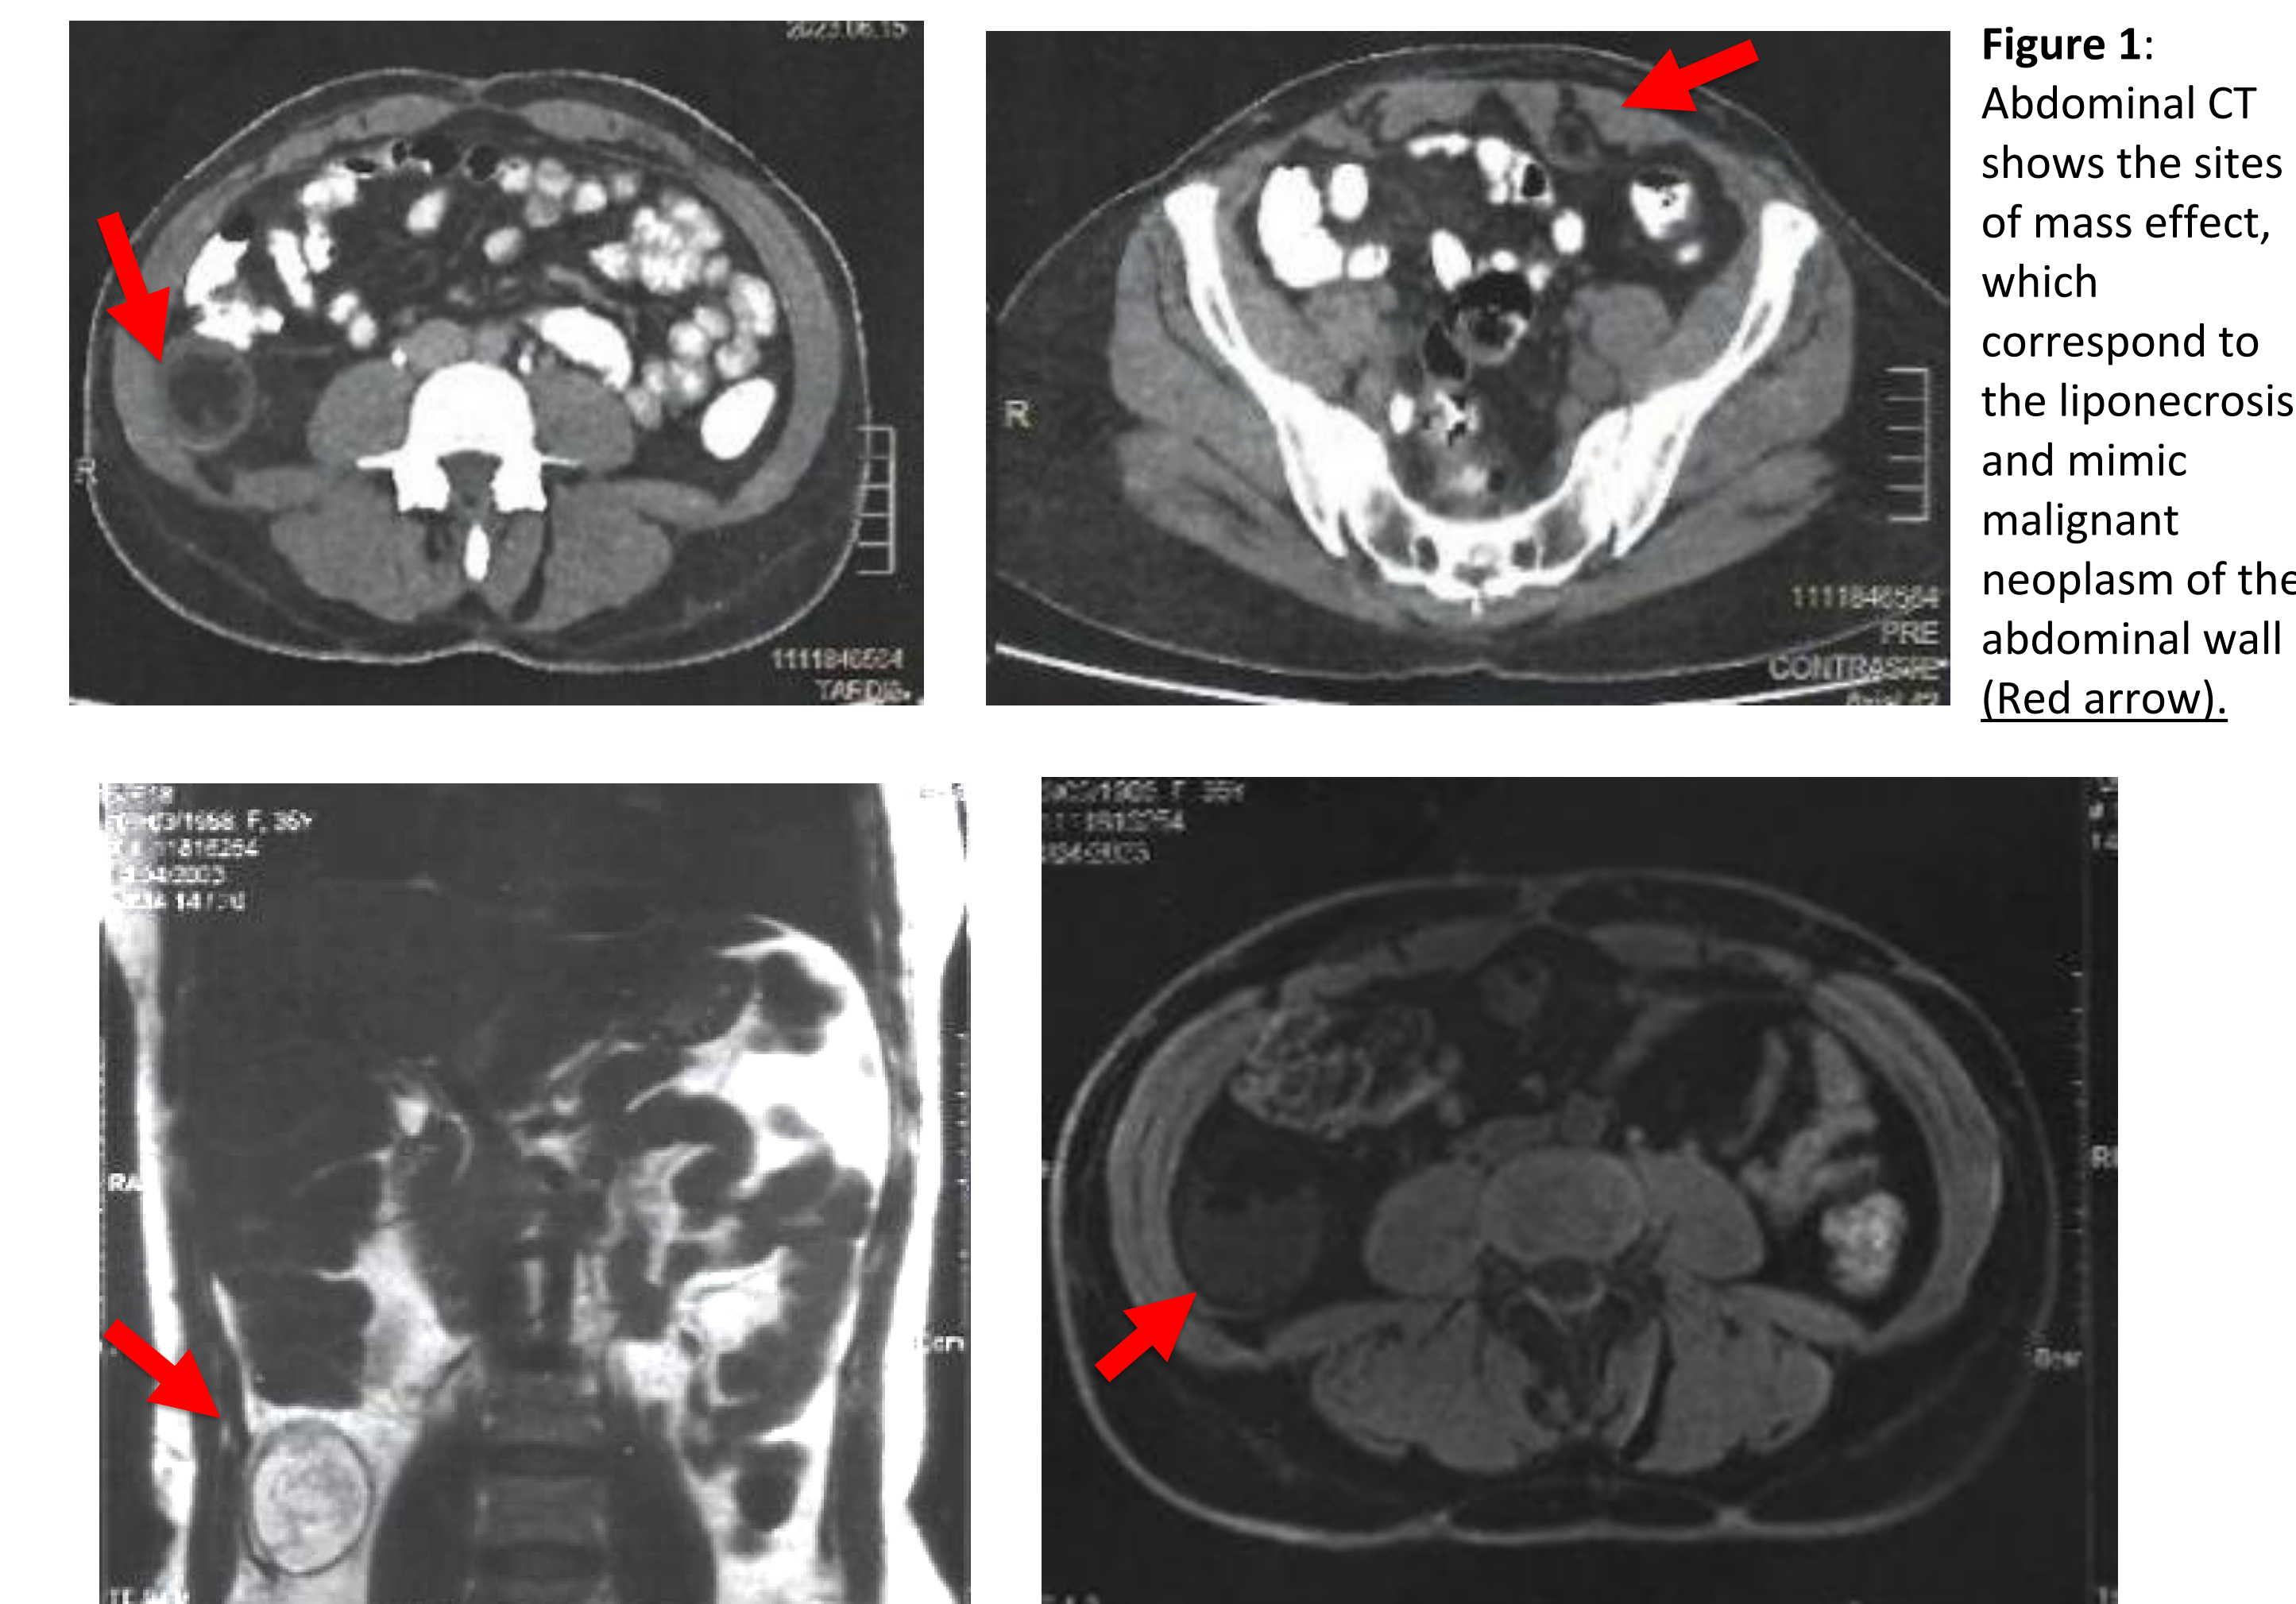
Abdominal CT shows the sites of mass effect, which correspond to the liponecrosis and mimic malignant neoplasm of the abdominal wall (Red arrow).
